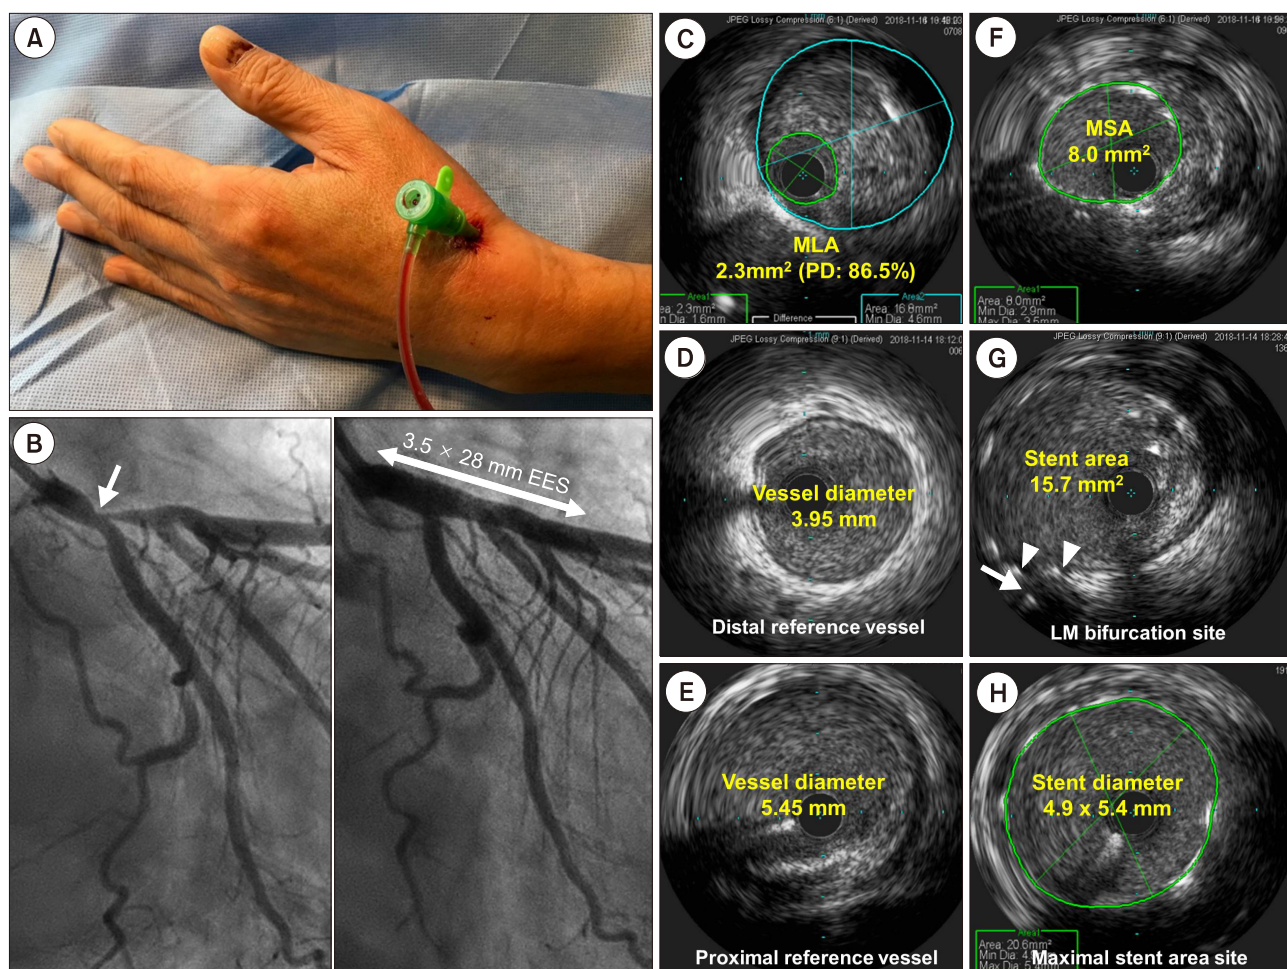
(A) Inserted 6 French sheath via left snuffbox approach. (B) Urgent CAG demonstrating the severe stenosis in the left main bifurcation site (arrow, left) and post-PCI CAG demonstrating successful stenting with POT of the left main bifurcation site (right). (C) IVUS imaging demonstrating MLA of 2.3 mm^2 and plaque burden of 86.5%. (D, E) Pre-PCI IVUS demonstrating distal and proximal reference vessel diameter of 3.95 mm and 5.45 mm, respectively. (F) Post-PCI IVUS demonstrating MSA of 8.0 mm^2 . (G) IVUS cross-section demonstrating stent area of 15.7 mm^2 and good strut apposition (arrowheads) in the left main bifurcation site (arrow, wire in LCx). (H) Post-PCI IVUS demonstrating DES overexpansion and stent diameter of 4.9 and 5.4 mm at maximal stent area site. CAG: coronary angiography, DES: drug-eluting stent, EES: everolimus-eluting stent, IVUS: intravascular ultrasound, MLA: minimal lumen area, LCx: left circumflex artery, PCI: percutaneous coronary intervention, POT: proximal optimization technique.
